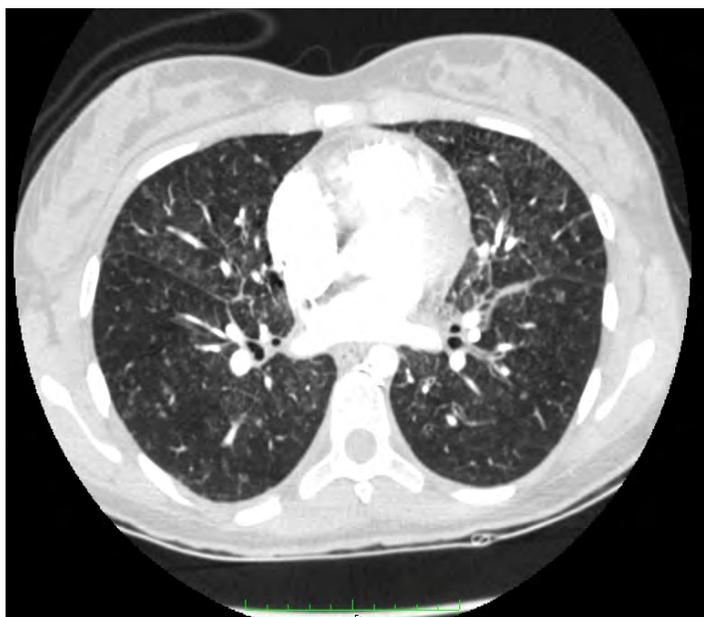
The second CT angiogram revealed signs of pulmonary hypertension, progression of multiple bilateral nodules of ground-glass opacity, signs of peribroncovascular edema and interstitial edema.
